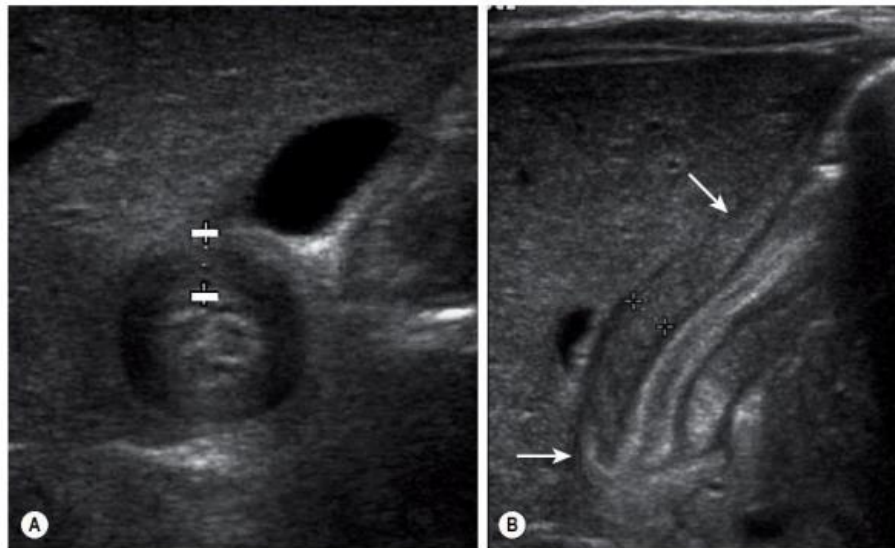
■ Ultrasonography has become the standard imaging study for diagnosing pyloric stenosis and has supplanted physical examination at most institutions. The (A) transverse and (B) longitudinal views of hypertrophic pyloric stenosis are seen here. Muscle thickness greater than or equal to 4 mm on the transverse view or a length greater than or equal to 16 mm on the longitudinal view is diagnostic of pyloric stenosis. On this study, the pyloric wall thickness was 5 mm and the length (arrows) was 20 mm.
